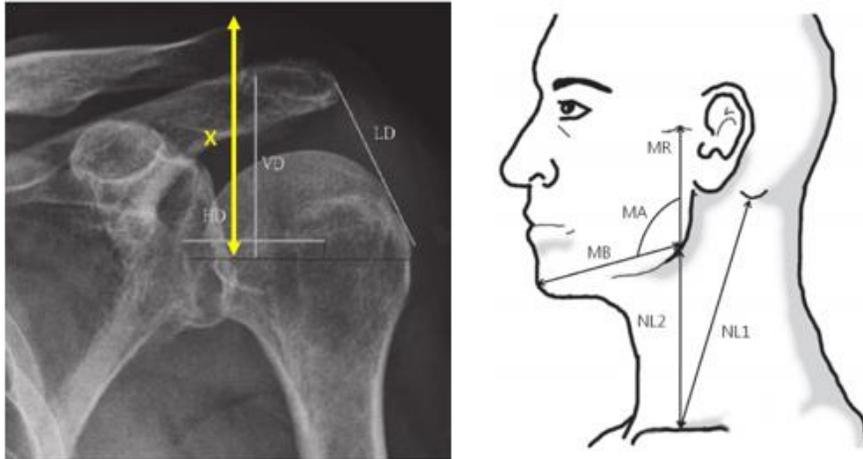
(Left) Distance from the shoulder joint to the surface of the shoulder is calculated based on the radiograph of upper limb [13]. (Right) Neck Length is considered based on the average distance NL2 measured among the patients [14].
